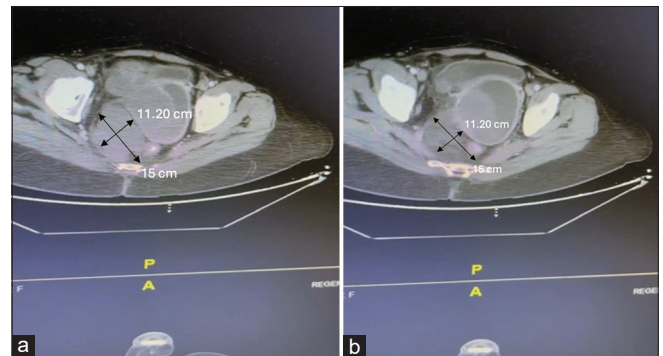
(a) computed tomography (CT) scan with contrast. (b) CT scan with contrast
